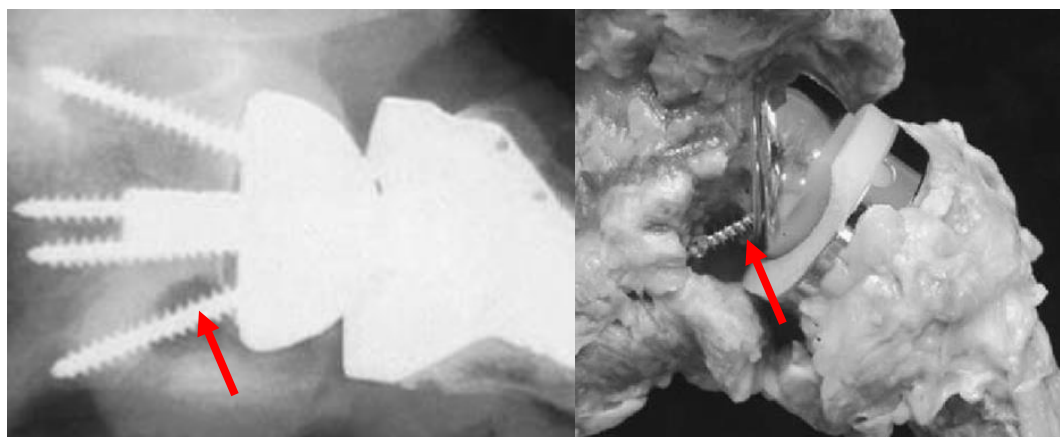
Radiograph and ex-vivo image of shoulder retrieval experiencing scapular notching. The arrow shows scapular notching as evidenced by radiolucency present near the inferior screw region denoting bone loss. In the right image, the arrow points to the area of scapular notching with the fixation screws visible. In addition, not seen in the radiograph, the polyethylene cup has been significantly damaged from repetitive contact with the exposed screw. Taken from Nyffeler et al. 2004.
